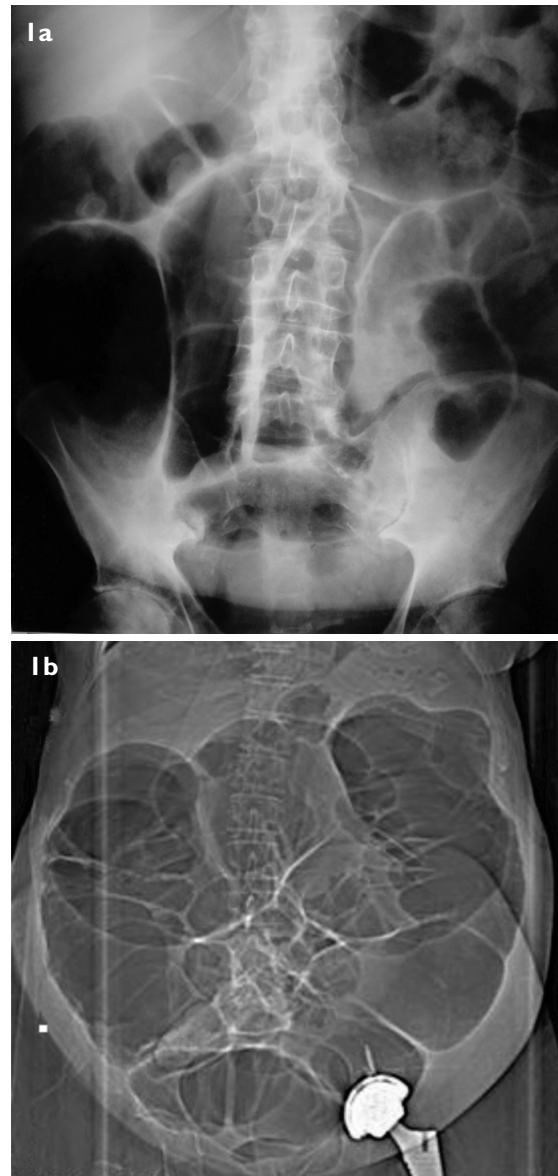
(a) Supine radiograph of the abdomen of a patient with intestinal pseudo-obstruction shows a dilated large bowel. It resolved after insertion of a rectal tube. (b) Axial CT image shows intestinal pseudo-obstruction three days after arthroplasty of the left hip. It resolved after opioids were stopped.
